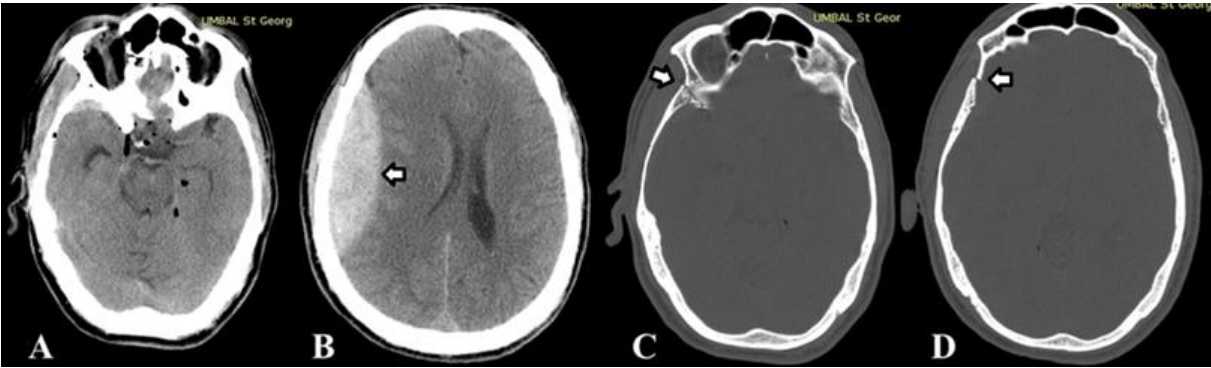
CT images of: A/ pneumocephalus; B/ epidural hematoma; C/ skull base fracture and D/ calvarian fracture
